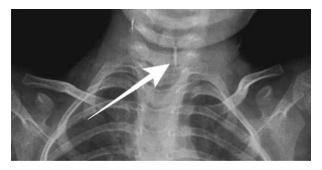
X-Ray Chest- Frontal view shows elongated pointed foreign body of metallic density (arrow) in the airway at C6-C7 level.
